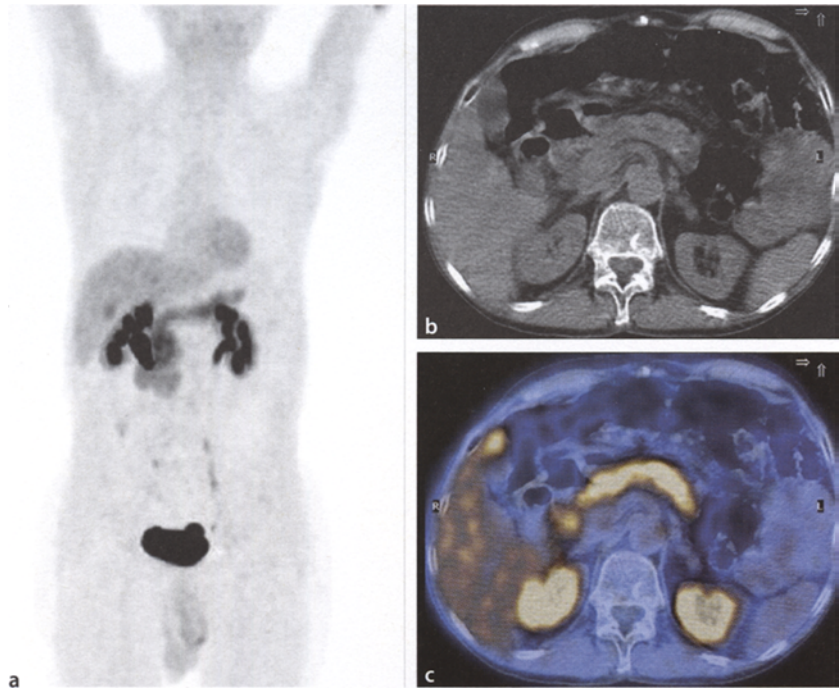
F-18 DOPA PET/CT showing physiological high uptake in the pancreas: MIP image (a), CT scan (b), and PET/CT fusion image (c). (Image courtesy of Stefano Fanti, University of Bologna)
